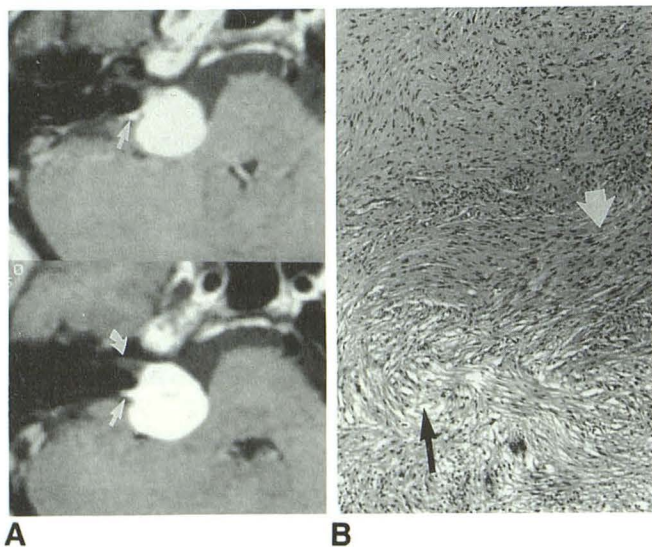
Dural tail associated with an acoustic schwannoma on contrast-enhanced MR imaging.
